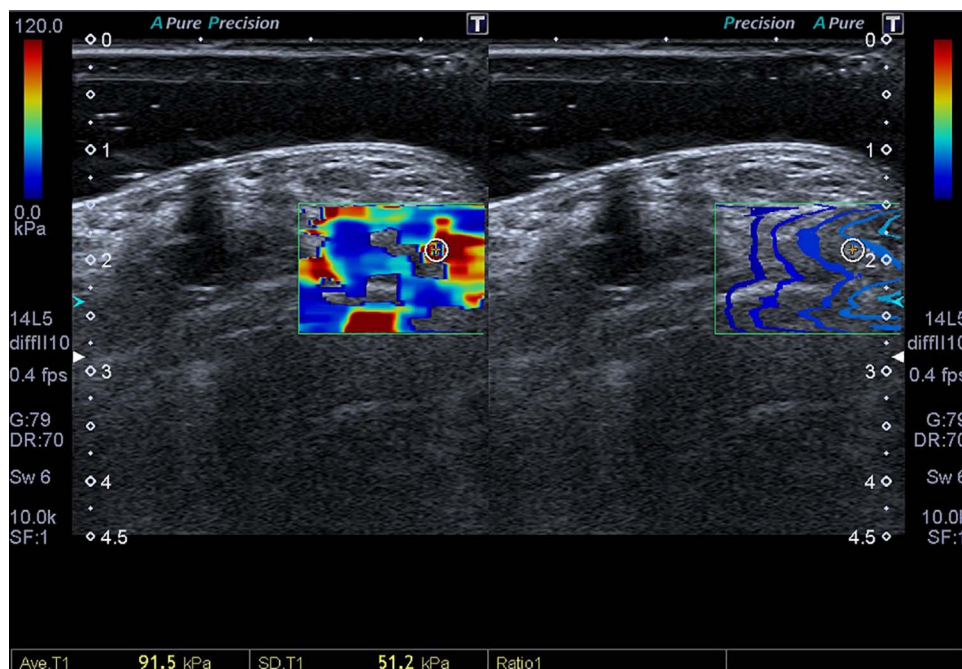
A 34-year old healthy female volunteer, axial sonographic image of the first extensor compartment of the wrist. Circle ROI depicts the area where SWE measurements were performed.
